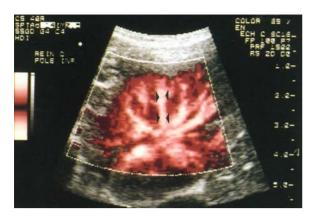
Transverse power Doppler US scan of the left kidney in a normal child. Normal intrarenal vessels. The straight course of interlobar arteries (*arrowheads*) is shown
